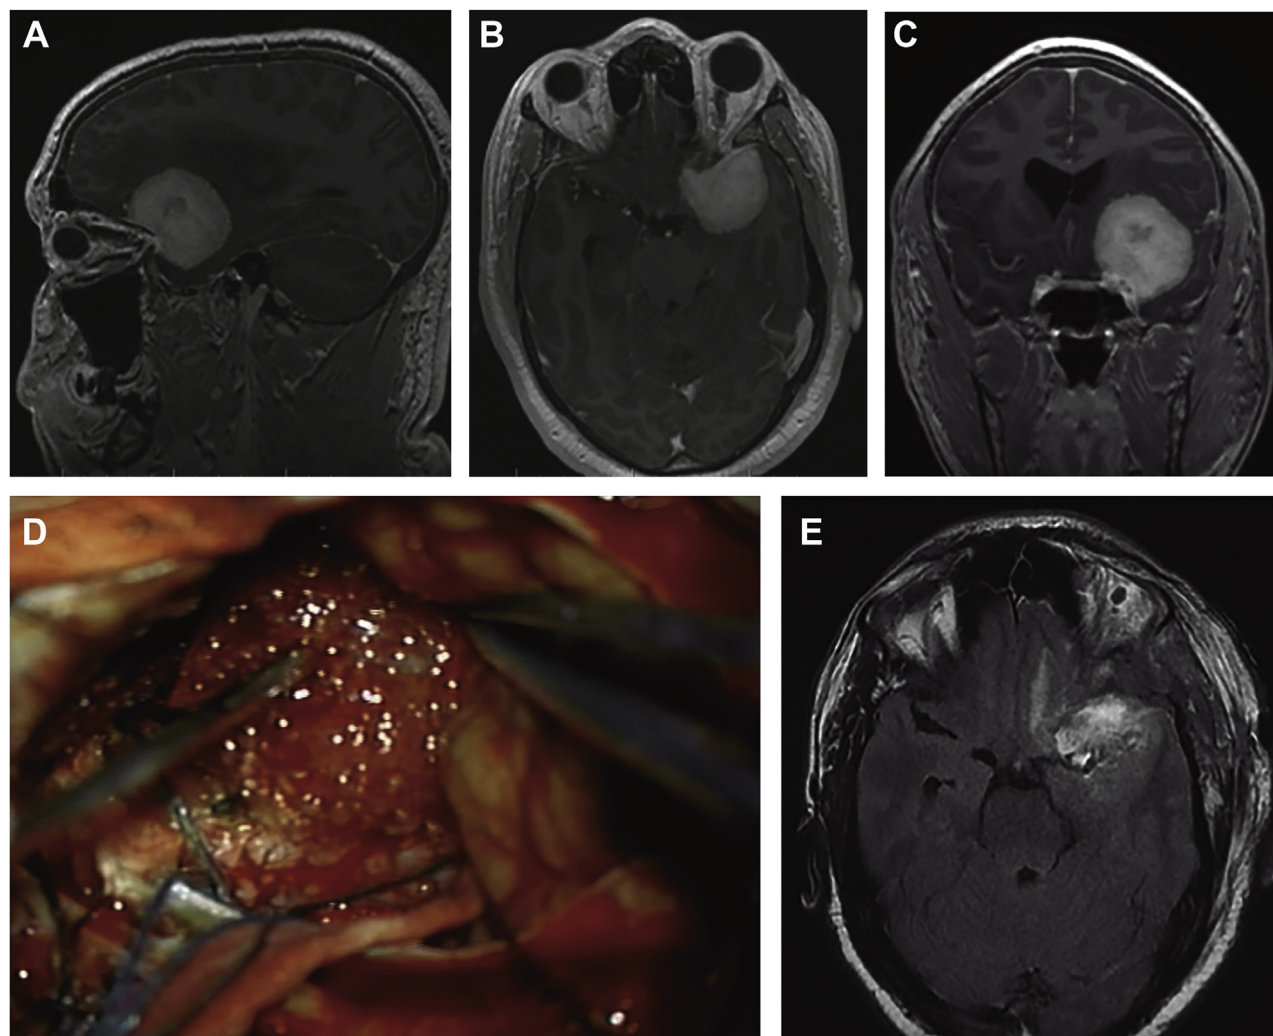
(A–C) Magnetic resonance imaging with gadolinium demonstrating a left side medial sphenoid wing and anterior clinoidal meningioma measuring 4.5 cm in diameter and causing significant mass effect on the frontal and temporal lobes with perilesional edema. Sagittal
